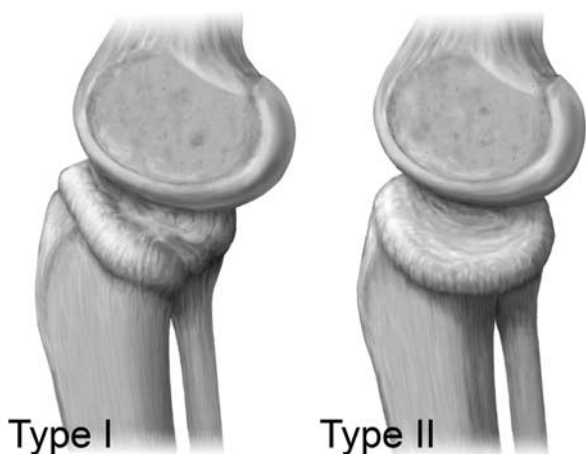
Type I and type II deformity patterns of the medial tibial plateau were seen. Type I, both medial and posterior slopes were present. Type II, only the medial tibial slope inclination was noted. Increased central depression of the medial tibial plateau was seen radiographically in both types.
